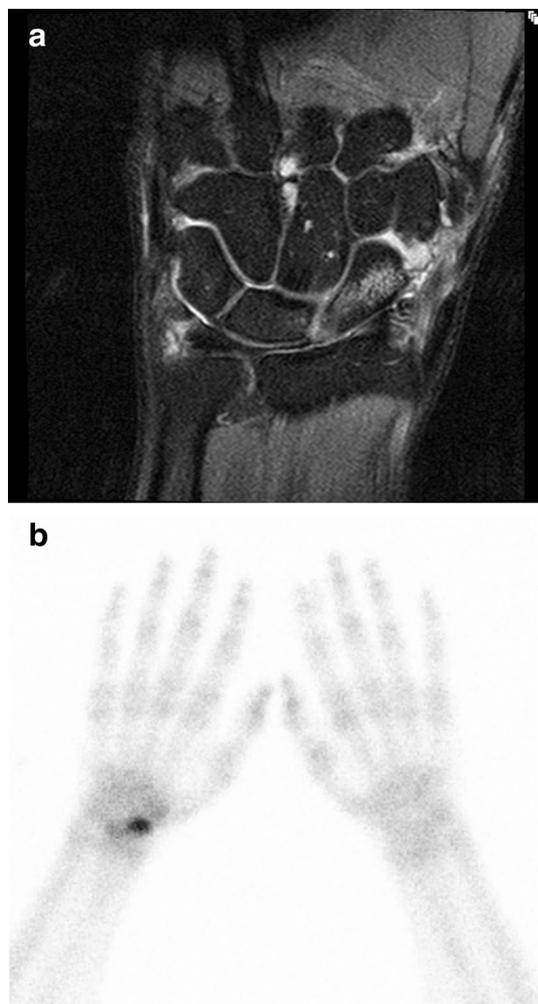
a T2 MRI image showing bone oedema and interruption of trabecular bone. The radiologists reviewed this as a trabecular scaphoid fracture. b BS showing activity in the scaphoid area, reviewed as a scaphoid fracture
